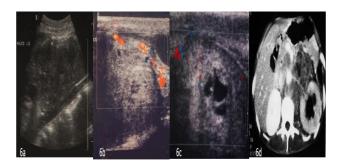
NSGCT; (a) The patient presented with abdominal lump. On sonography a large hetroechoic mass lesion noted in the epigastric region anterior to aorta; (b) Associated scrotal swelling revealed a heterogeneous mass lesion with cystic and hyperechoic areas. On Doppler increased peripheral vascularity noted. (c)Multi oculated cyst with thick shaggy wallsurrounded by heterogeneous testis (d)-Large confluent lymphnodal mass is noted in the paraaortic, aorto-caval, and around renal hilum. Bilateral hydronephrosisseen.
